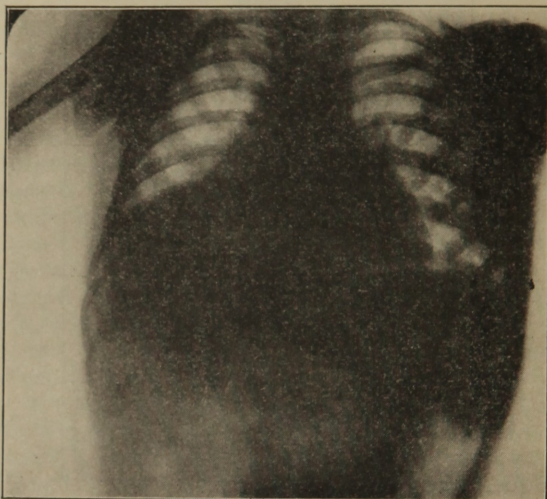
Radiograph of a purulent “sponge soaking” of the lung following the inhalation of a fragment of peanut kernel. Note the dark shadow in the region of the right lower lobe, in which a small particle of the peanut lodged. Several small pieces were removed bronchoscopically, but the fragment which remained produced septic pneumonia and pulmonary abscess.
